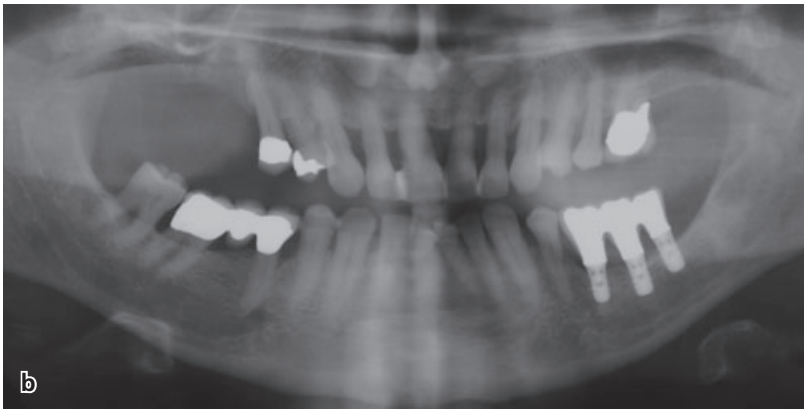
(a) Intraoral clinical image of the same patient after prosthetic reconstruction of the lower left quadrant with three short implants and a three-unit fixed partial denture. Note the resulting extensive crown heights. (b) Panoramic radiographic image of the implant restoration in the lower left quadrant using three 6 mm long implants. Five-year follow-up. The patient decided to wait with any prosthetic treatment of the upper right quadrant, where a vertical ridge augmentation combined with external sinus elevation is required.
